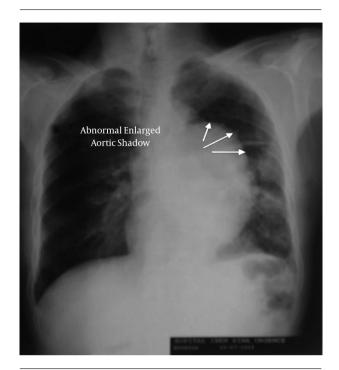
Chest Radiography Shows Abnormal Aortic Shadows
